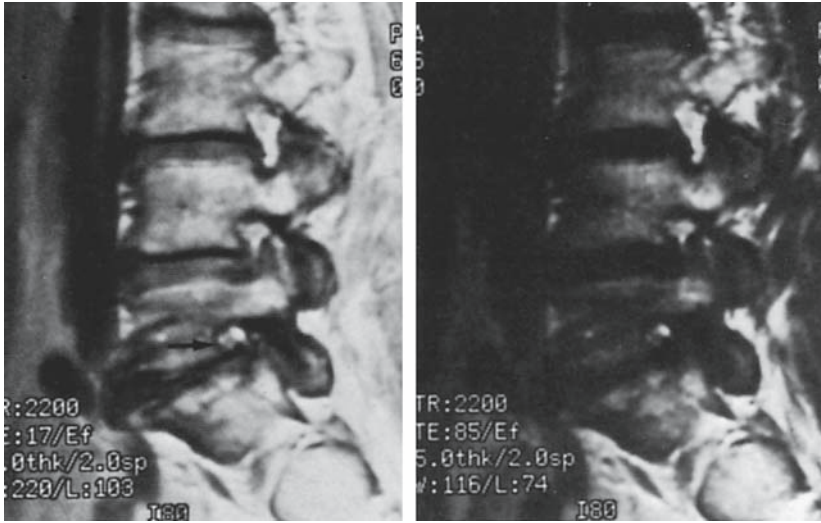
Magnetic resonance imaging of the lumbar spine. Sagittal view of a T₂-weighted image demonstrates foraminal narrowing at the L5–S1 interspace (*black arrow*) with associated intervertebral disk degeneration. (From Borenstein DG, Boden S, Wiesel SW. *Low Back Pain: Medical Diagnosis and Comprehensive Management*, 2nd ed. Philadelphia: Saunders, 1995. Reprinted by permission.)
